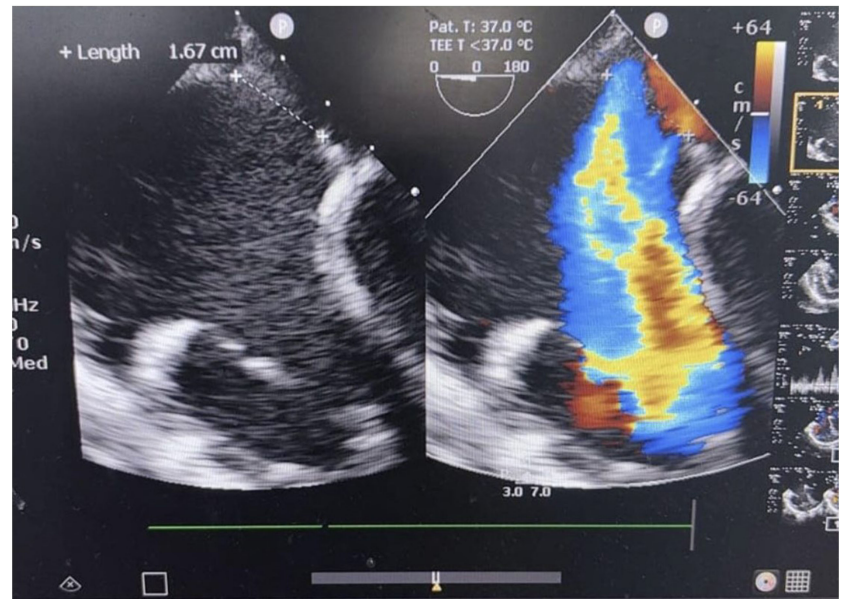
(a). Transoesophageal echo with mid oesophageal four chamber view showing the atrial septal defect with bidirectional shunt.
